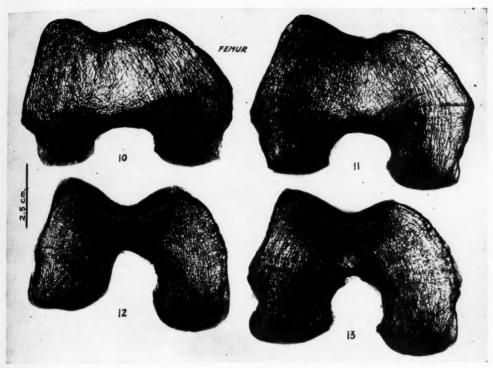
Plate V, Figs. 10 to 13. Roentgenograms of cross-sections of the lower extremity of the femur. One-fifth reduced. There is a series of diverging bone trabeculæ radiating from the intercondyloid fossa in the lower end of the femur. These are produced by the back-pressure of the crucial ligaments in alternate traction, during flexion and extension of the knee joint. Albert (1900) calls these the "radiant" trabeculæ, but he adds: "What mechanical meaning this texture may have, will have to be found by later research" (page 48; see Footnote 17 for citation).
